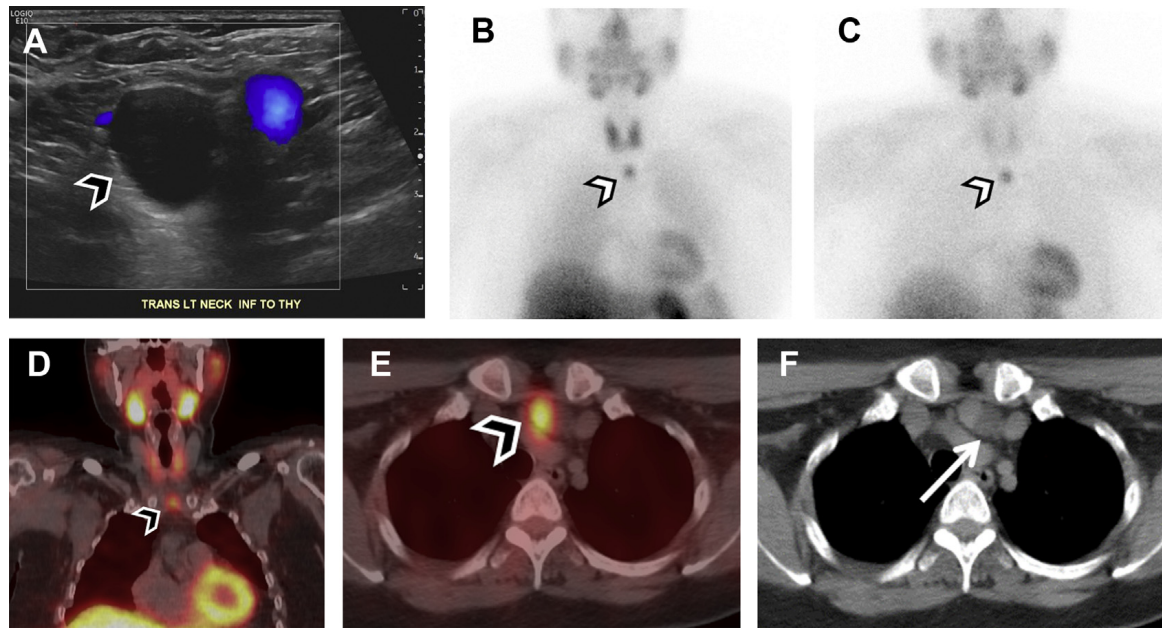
Ectopic parathyroid adenoma on sestamibi scan. (A) Neck ultrasound identified a cyst (arrowhead) inferior to the left thyroid lobe. Sestamibi scan confirmed radiotracer uptake in the superior mediastinum on (B) immediate images, with persistent uptake on (C) 2-hour delay images (arrowheads). Findings were confirmed on SPECT/CT as seen on fused (D) coronal and (E) axial images (arrowheads), and on (F) correlative CT, which demonstrates the partial cystic component (arrow). On surgery, the patient was found to have a cystic parathyroid adenoma in the superior mediastinum (of which the cystic component was only partially visualized on neck ultrasound).
